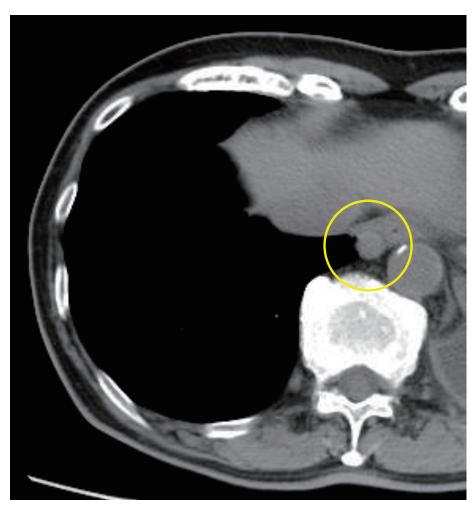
Chest computed tomography 3 years before surgery (mediastinal window)
